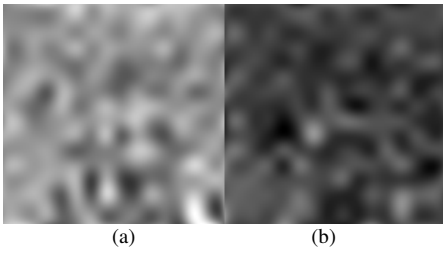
Trabecular bone in CT L3 vertebra for children with a normal (a) and low BMD (b).
